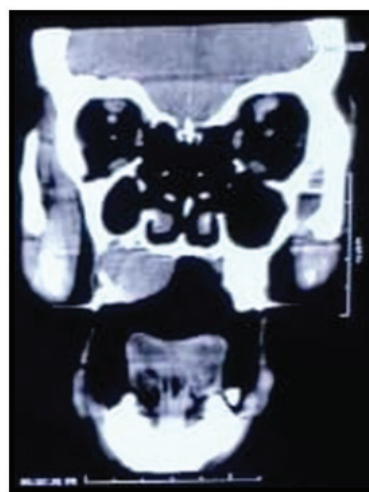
CT scan -Axial view
